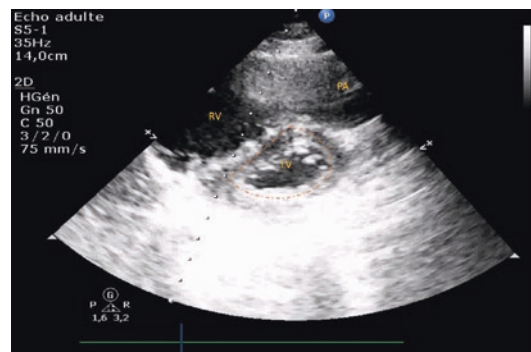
Right ventricle dilatation during major pulmonary embolus with D sign in parasternal short axis
